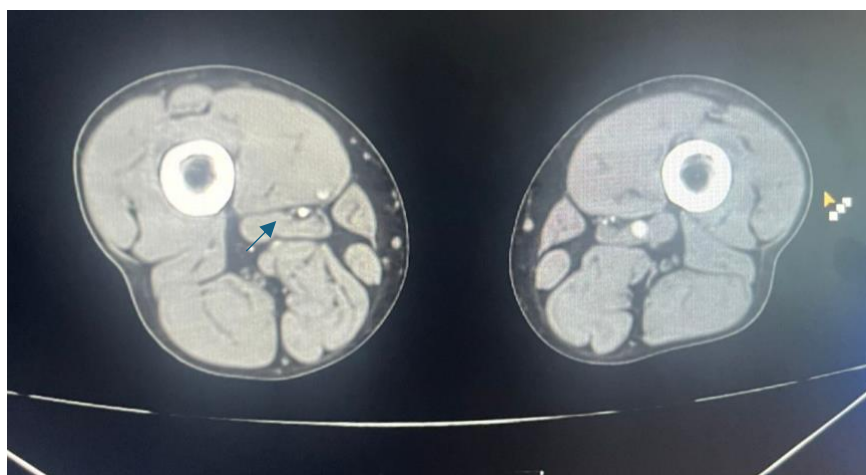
CT angiography revealed a thrombus completely occluding the superficial femoral artery.
